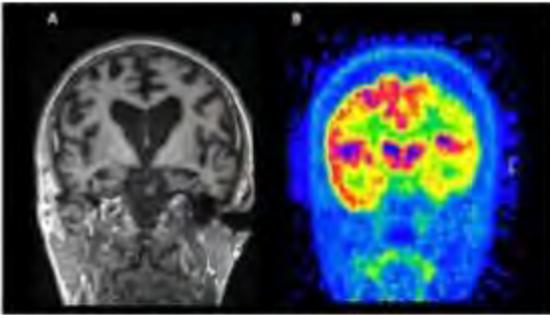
Structural MRI (left) and FDG PET (right) in AD.
